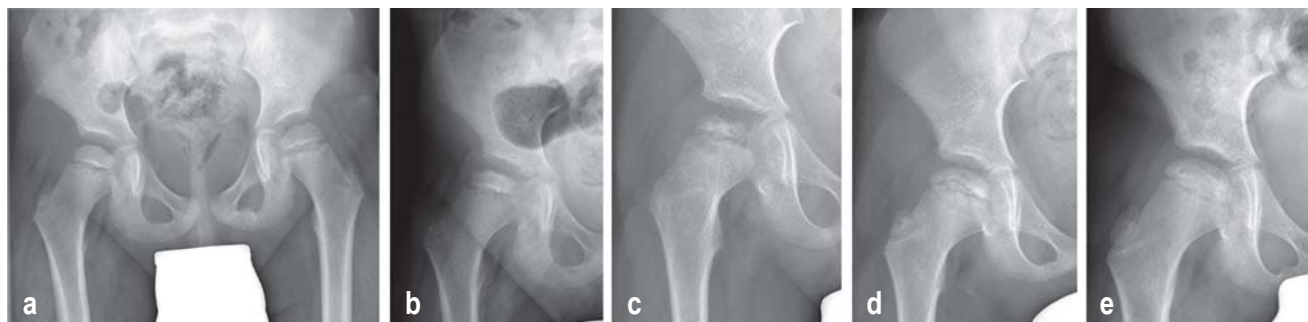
Radiographic staging of Perthes disease (Waldenström classification)
